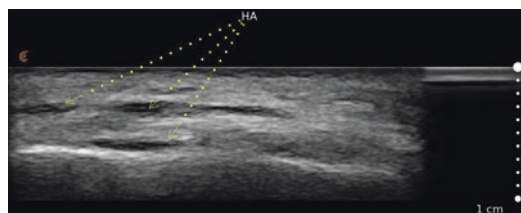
Grayscale ultrasound image of cheek immediately after injection of hyaluronic acid filler. Anechoic deposits of the filler are seen within the fat of the cheek
